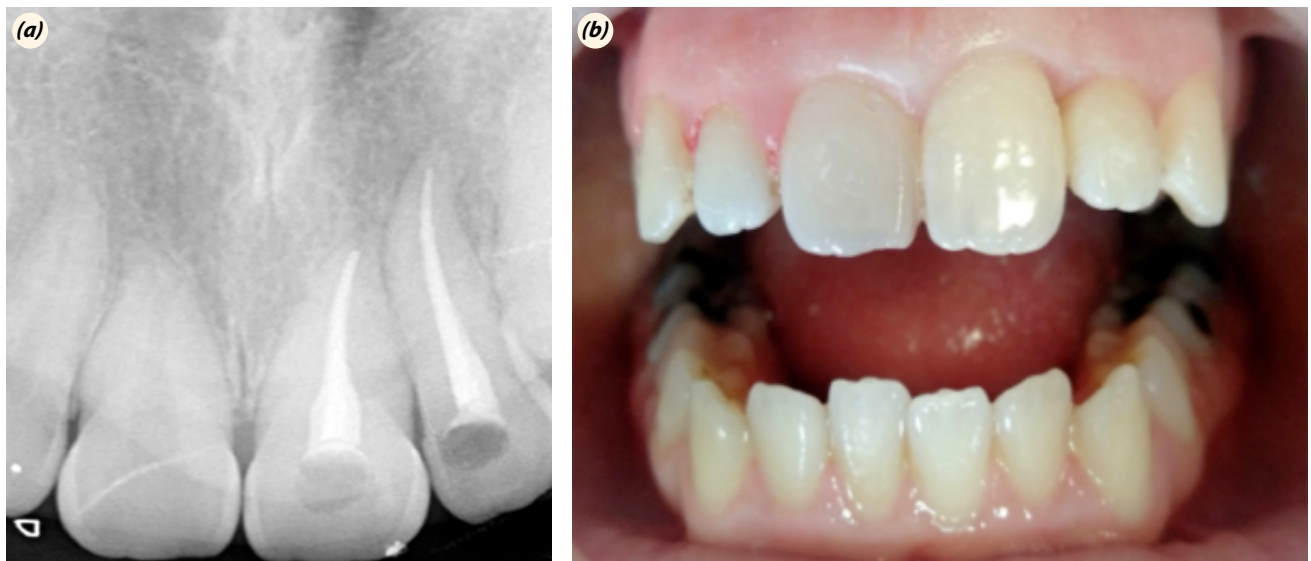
Periapical radiograph demonstrating root canal treatment (a). Clinic view of maxillary left incisor two week later (b).
